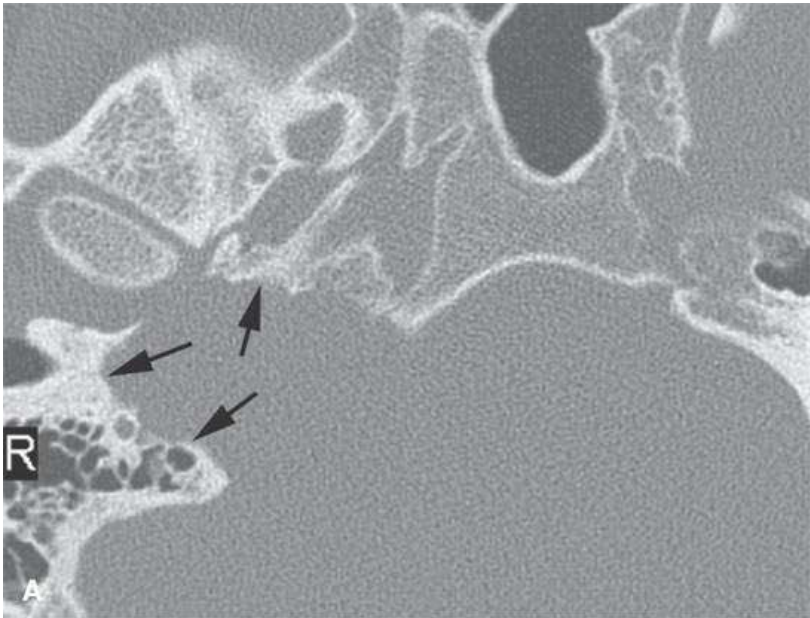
Images of a patient with a jugular fossa schwannoma. A: Computed tomography shows smooth regressive remodeling (*arrow*) of the walls of the jugular fossa (contrast with the pattern in Figure 21.29). B: Contrast-enhanced T1-weighted image for comparison.
